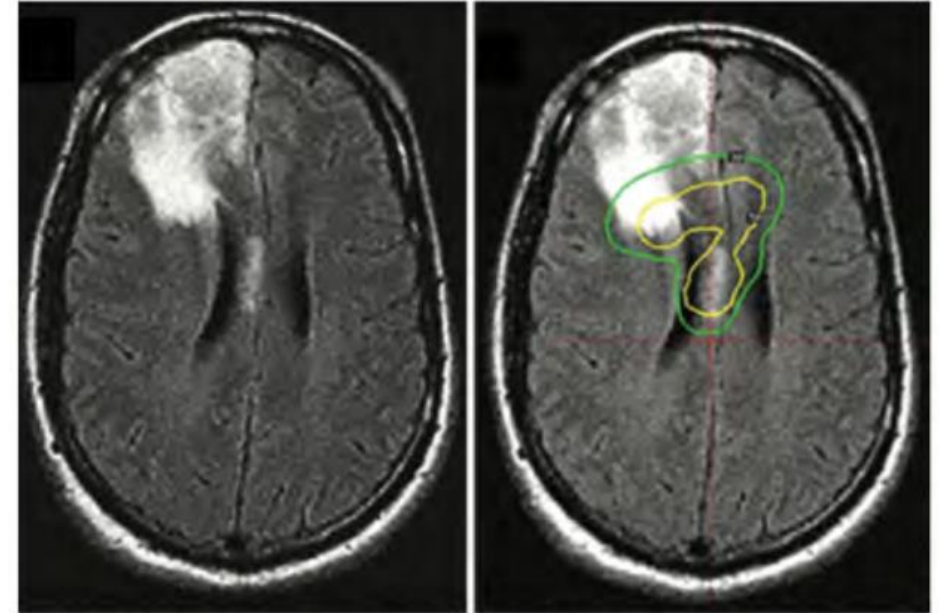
Left: Distant “invisible” tumor spread into the corpus callosum as revealed on FLAIR sequence seen in Fig. 1. Right: Gamma Knife LERS plan used to arrest migration. A 10-Gy dose at the 50% isodose line was prescribed.
